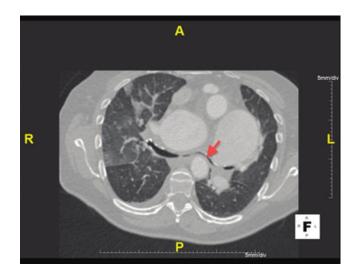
Contrast-enhanced computed tomography image of patient A showing left main bronchus compression (arrow) by the main pulmonary artery.
